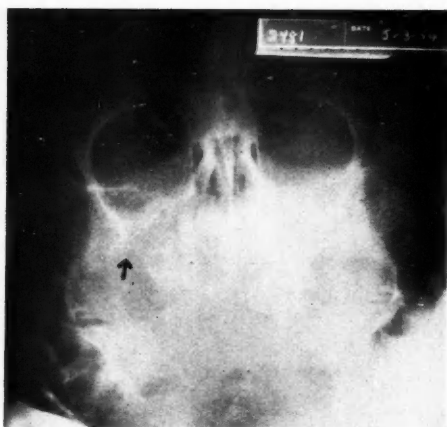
Case 1. Occipitontal radiograph six months after sequestrectomy. The arrow indicates the area of bone loss.
